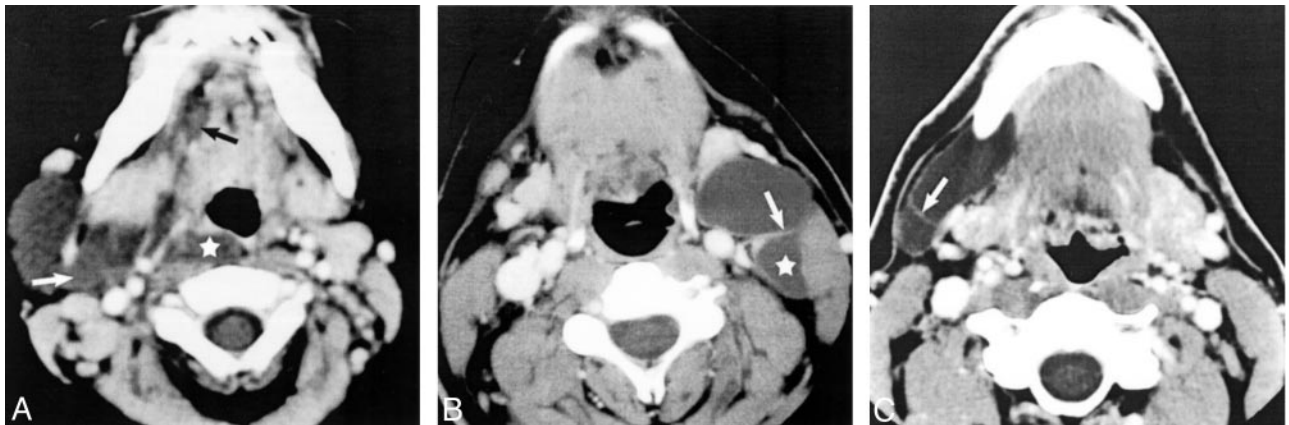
Axial view contrast-enhanced CT scans of three patients with cystic hygromas show helpful differentiating features.
